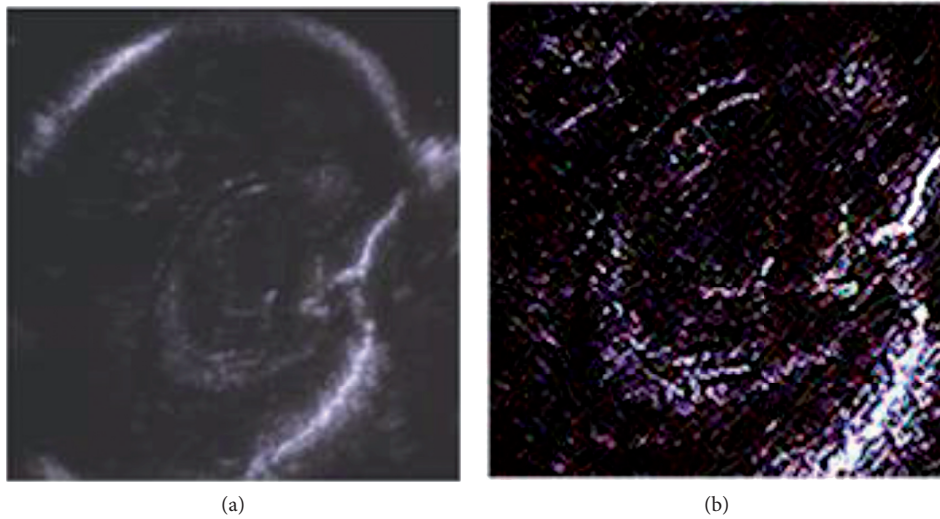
Comparison of lateral ventricle parasagittal sectional ultrasound images before and after treatment of normal fetuses: (a) experimental group; (b) control group.
